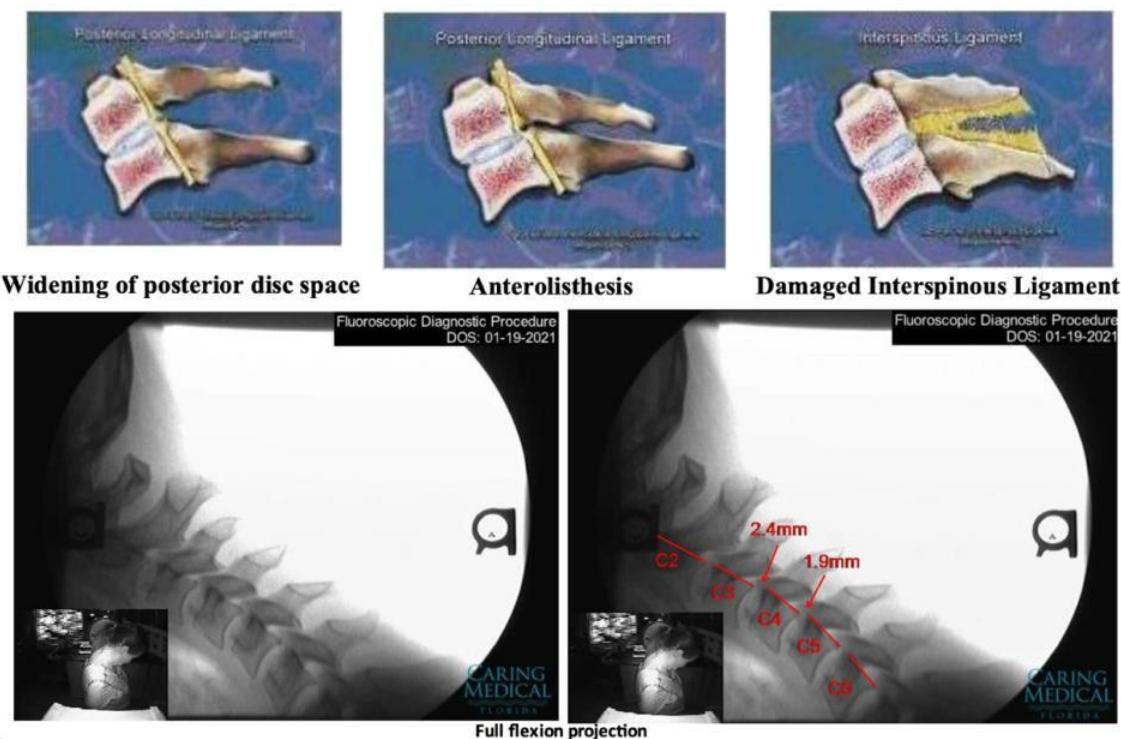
Digital Motion X-ray was performed and demonstrated cervical spinal instability. 2.4mm and 1.9mm anterolisthesis of C3 on C4 and C4 on C5 respectively in flexion. This view examines the integrity of the posterior longitudinal ligament demonstrated by a forward (anterior) movement of one vertebra over the vertebra below or by the posterior widening of the intervertebral disc space (increased disc angle). Image courtesy of Agnes Stogicza, used with permission of the patient, RB.
